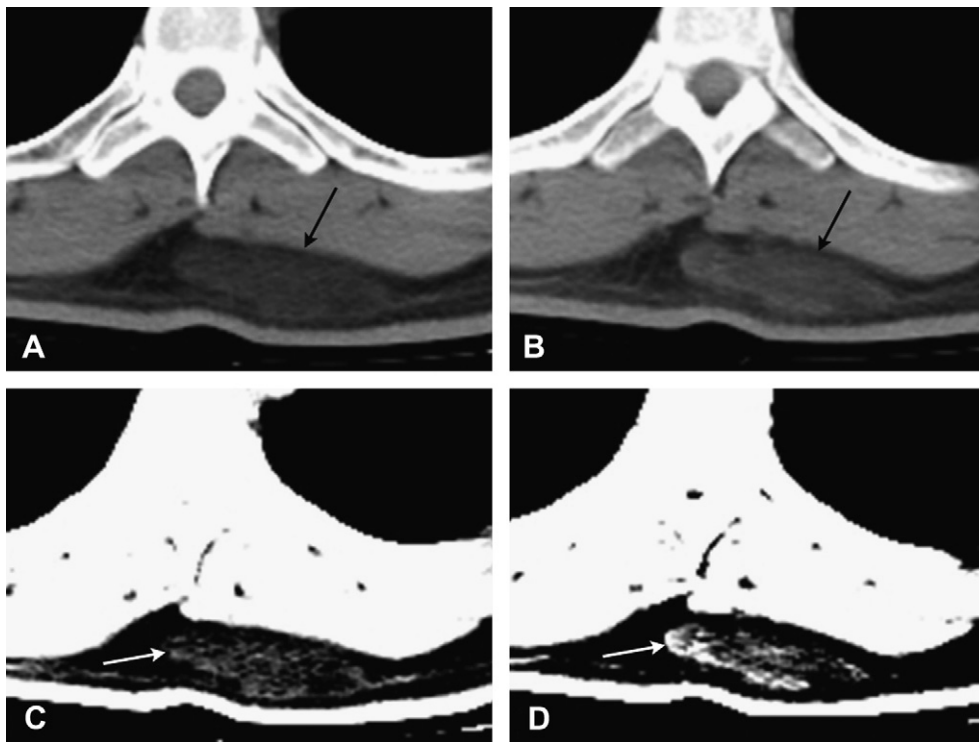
Axial chest CT scan with a focus on left side back before (A) and after (B) contrast administration. One well-defined mass (black arrows) located in the interscapular subcutaneous area with separation from the trapezius muscle. The mass showed an intermediate attenuation between fat and muscle attenuation and asymmetric marginal enhancement, which can be recognized more easily (white arrows) while comparing images before (C) and after (D) contrast administration by narrowing the window width of CT number. CT = computed tomography.
